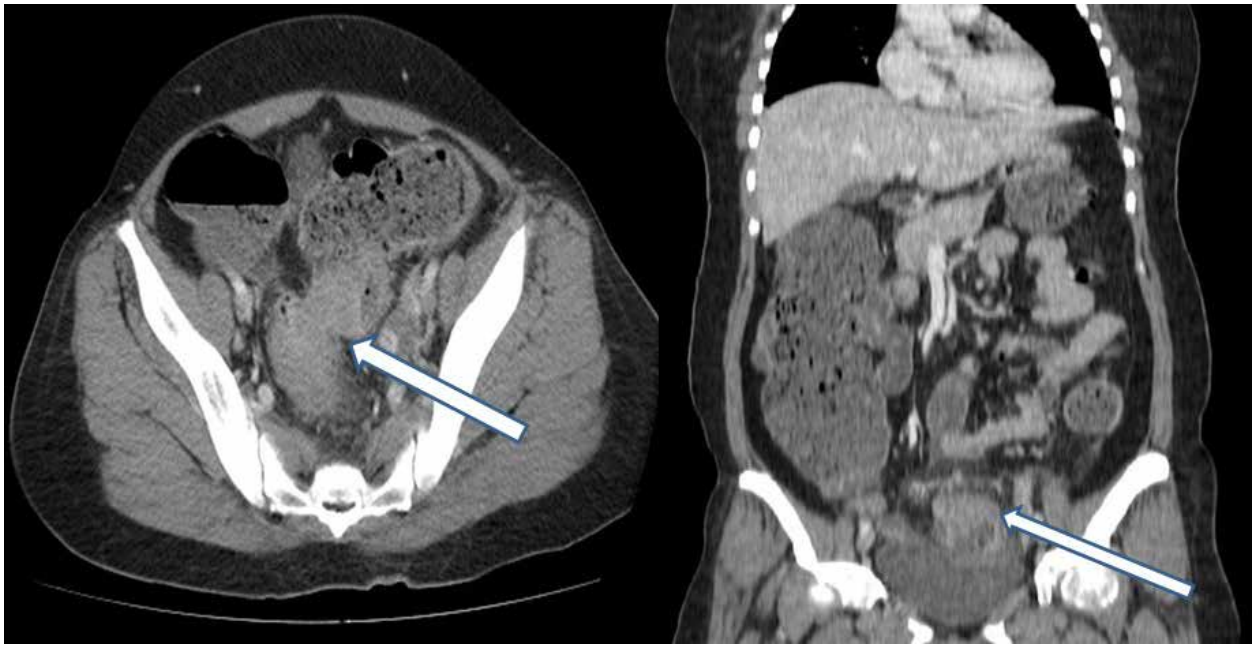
CT images: Rectosigmoid colon tumor and secondary mechanical intestinal obstruction images.
